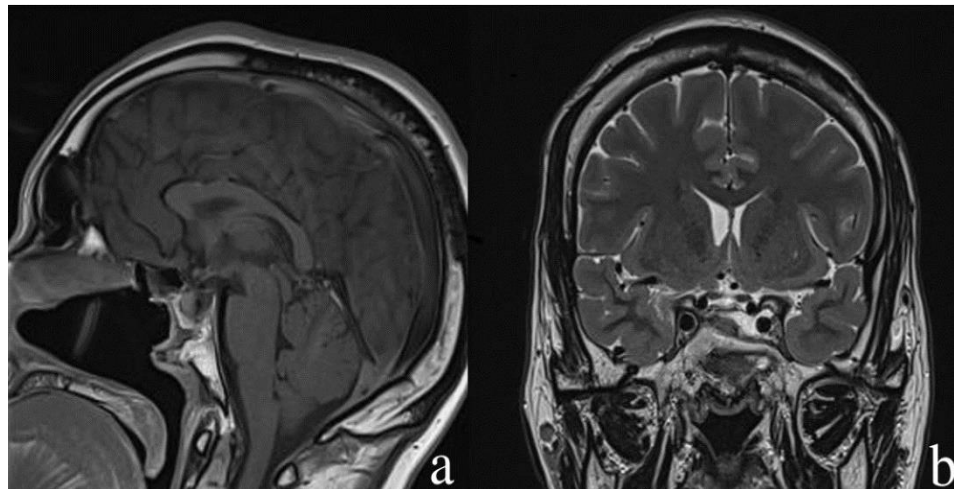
a- sagittal T1 with contrast showing the vascularized nasoseptal flap without CSF collection in the sinus. b- coronal T2 MRI showing a good response for medical treatment with tumor shrinkage.
